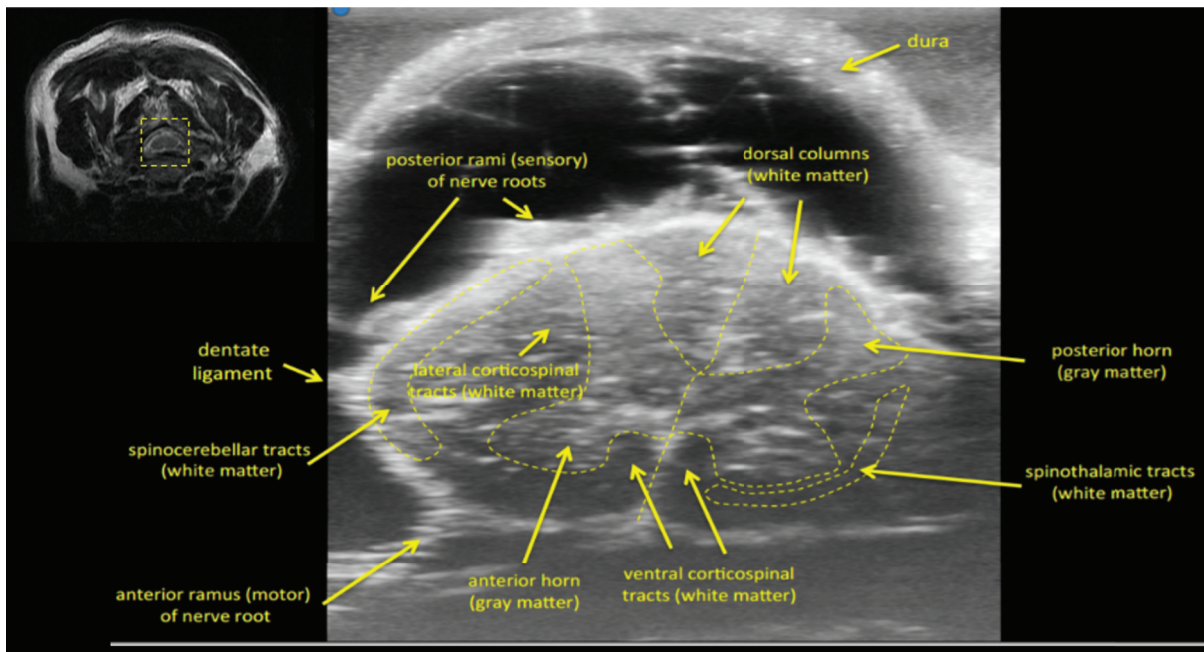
Spine decompression surgery: MRI (millimeter) to high frequency  $\mu$ US (micrometer) comparison shows clear definition of the spinal cord with clear delineation of white matter tracts, nerve roots, and vascular networks with micrometre resolution.
